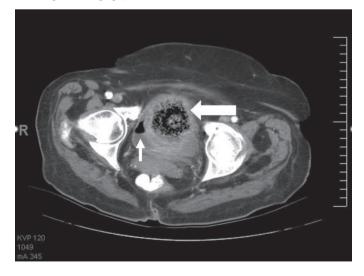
Axial views of CT scan of a patient with diverticulitis and pelvic abscess [wide arrow] with colovesical fistula and air in the bladder [narrow arrow] *CT: Computed tomography*
